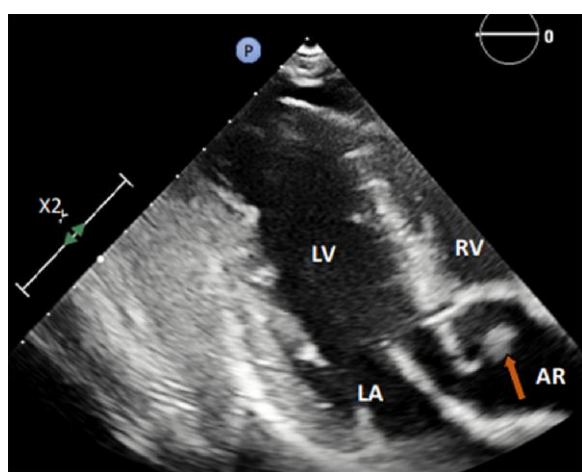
Transthoracic echocardiogram. Parasternal plane long axis. Nodular pedunculated mass dependent on the right coronary sigmoid valve leaflet (arrow). LV, left ventricle; RV, right ventricle; LA, left atrium; RA, aorta artery.
